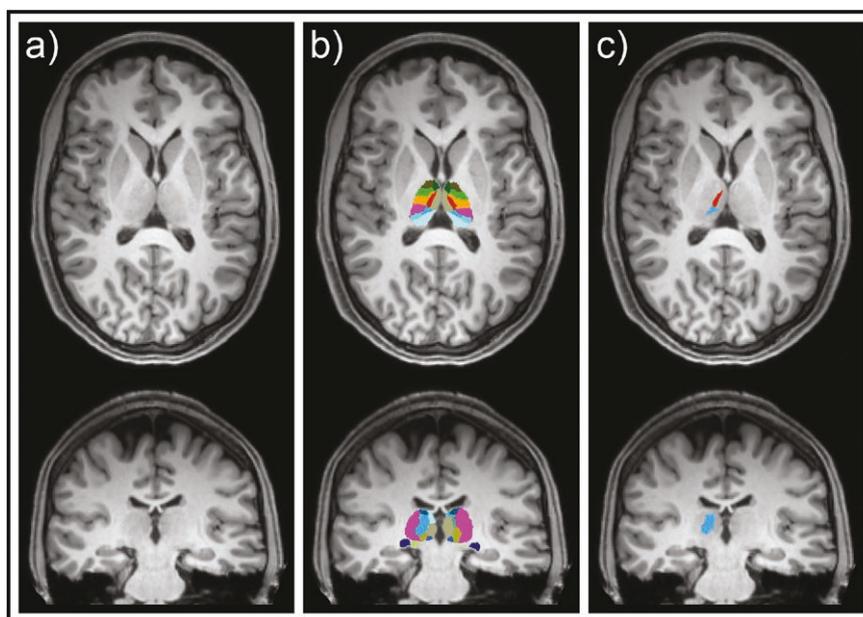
Visual representation of thalamic nuclei segmentation. Segmentation of the whole thalamus based on structural magnetic resonance imaging (MRI) data (a,b). Thalamic nuclei showing significant morphological adaptations after esketamine administration (c): right pulvinar anterior nucleus (blue) and right mediodorsal lateral parvocellular nucleus (red).
